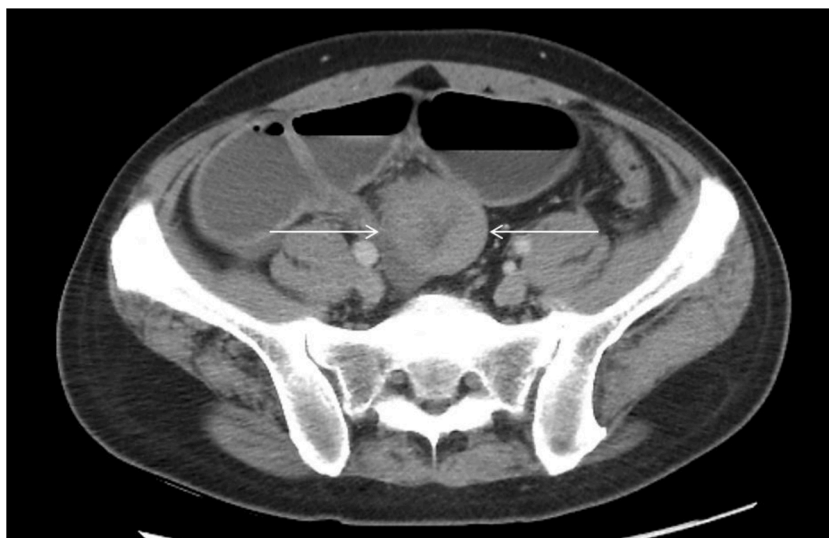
CT abdomen with ileocecal mass (arrows) measuring approximately 4.75 cm in diameter.
